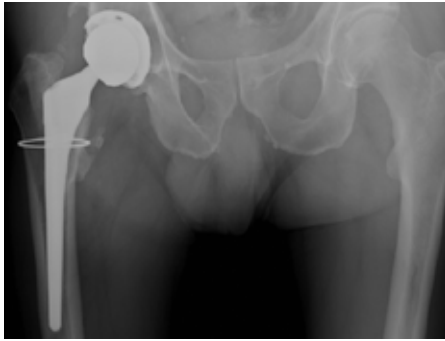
Preoperative AP radiograph of pelvis. Note small amount of heterotopic bone near lateral acetabulum and lesser trochanter.
